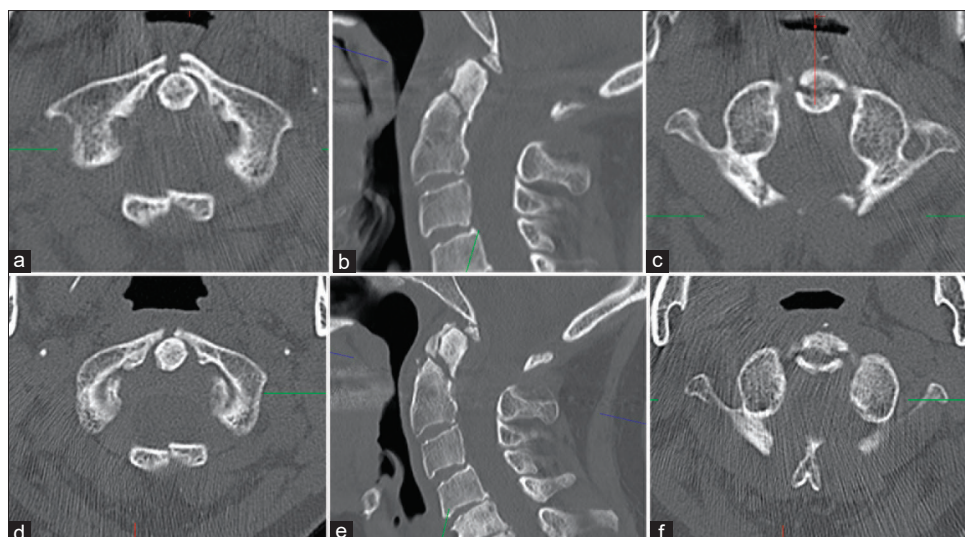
The patient is a 75-year-old woman who presented with neck pain after a ground-level fall. Computed tomography demonstrated (a) a type 3 atlas fracture and (b) type II dens fracture. She was managed conservatively with a rigid cervical orthosis (c). On follow-up CT 12 weeks following her initial injury (d, e, f), no bony bridging was noted of her atlas fracture or dens fracture, and the angulation of her dens fracture had progressed (e)
